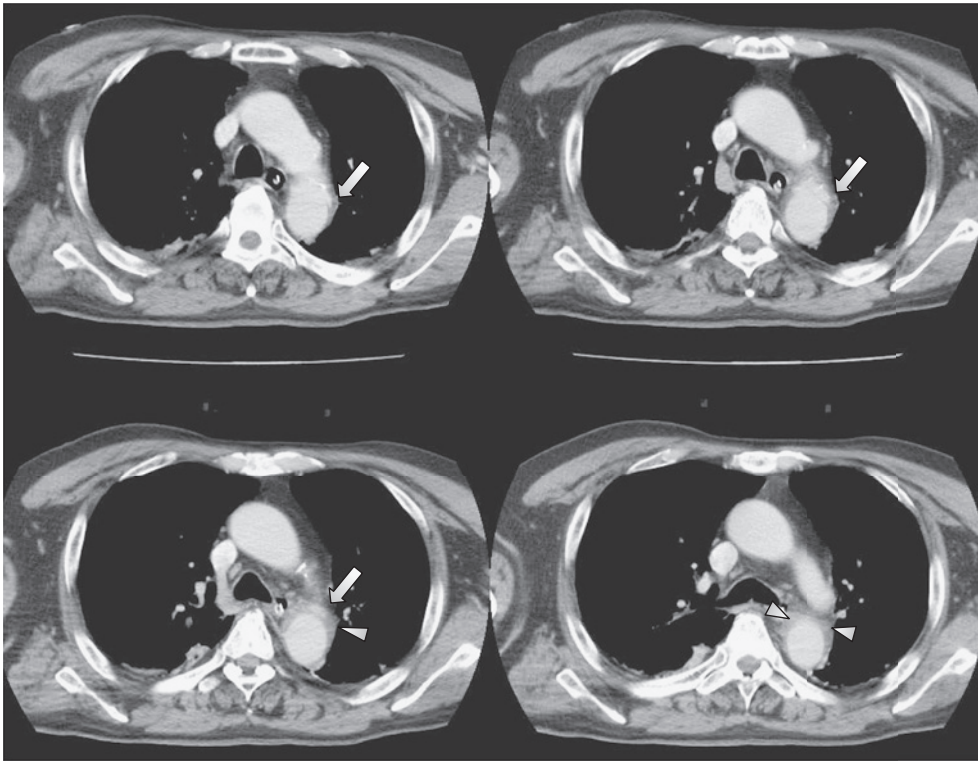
Initial contrast-enhanced CT of the chest shows a small pseudoaneurysm in the lesser curvature of the distal aortic arch (arrows), with a small mediastinal hematoma (arrowheads), indicative of thoracic aortic injury.
